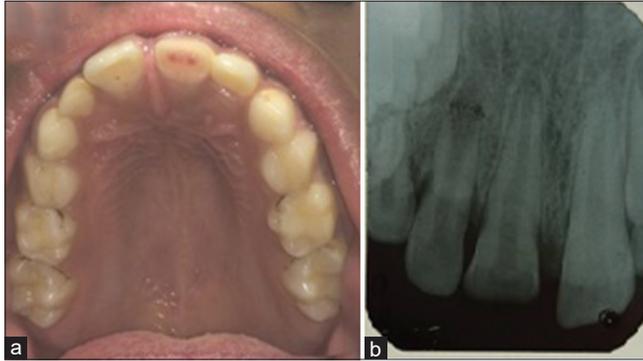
(a) Preoperative photograph showing Ellis class III fracture in 11 with pulpal exposure; (b) Preoperative radiograph revealing fracture in 11 with pulpal involvement.
